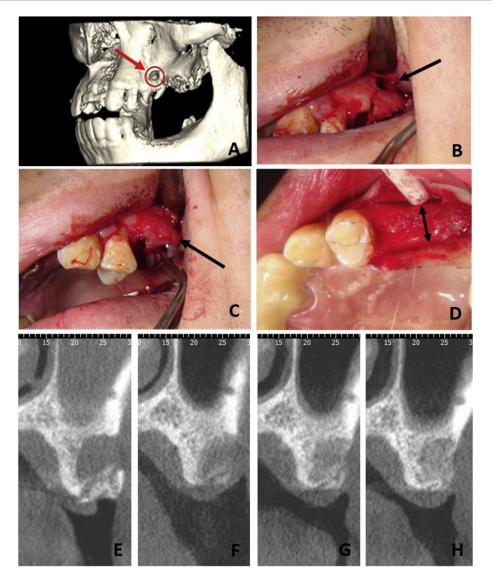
(A) Three-dimensional image of CBCT revealing a fenestration alveolar bone defect at the #25 region. (B) Clinical photograph showing a fenestration alveolar bone defect at the #25 region. (C) Clinical photograph for platelet-rich fibrin application over #25 alveolar bone defect. (D) After 6 months, the socket was completely filled with a hard material, which on probing exhibited the consistency of bone. The CBCT images demonstrated the changes of bone density (E) immediately after #25 extraction and (F) 2 months, (G) 4 months, and (H) 6 months after platelet-rich fibrin application. CBCT = cone beam computed tomography.
